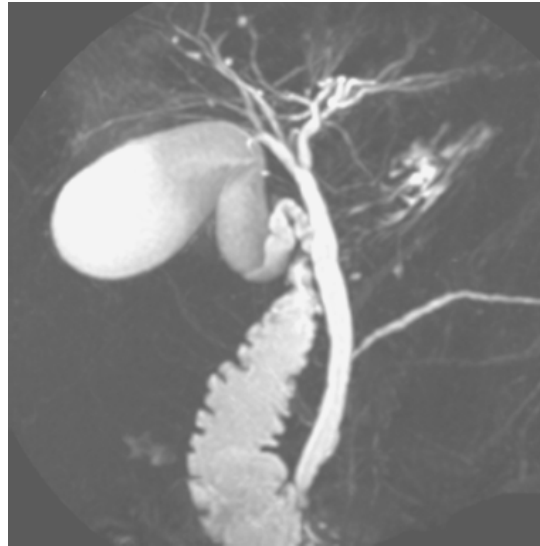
CT image of gall bladder
